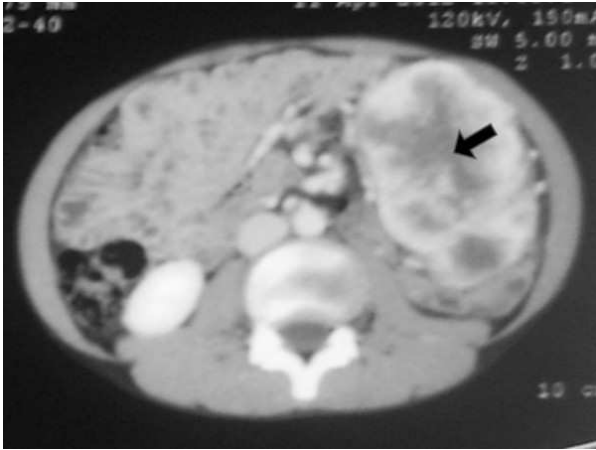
Computed tomography revealed a large mass (10.0x8.8x7.5 cm) in the pancreatic tail, mainly solid but with some cystic component (arrow).
